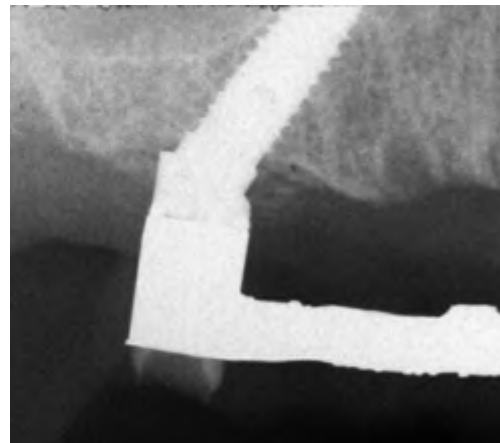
Periapical radiograph of the right distal implant/abutment/cylinder interface that demonstrated an accurate fit between the implant components. There was a retaining screw in the left distal portion of the prosthesis. Per the Columbus Bridge Protocol, the framework was not cantilevered distal to the last implant.
